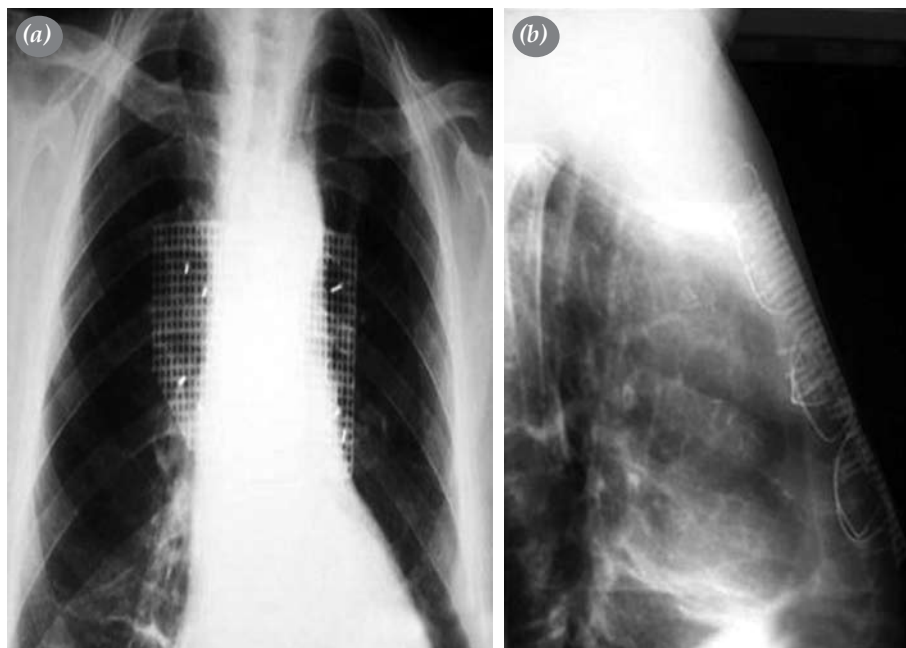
Are showing the plates and screws from the (a) postero-anterior and (b) lateral chest X-ray film.
